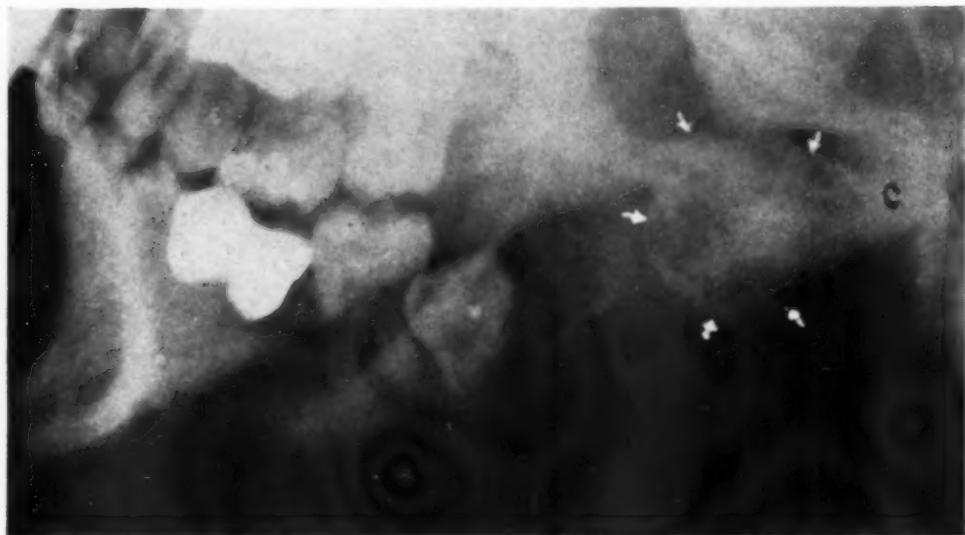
Lateral x-ray film showing hyperostosis of right mandibular joint. Note condyle.
